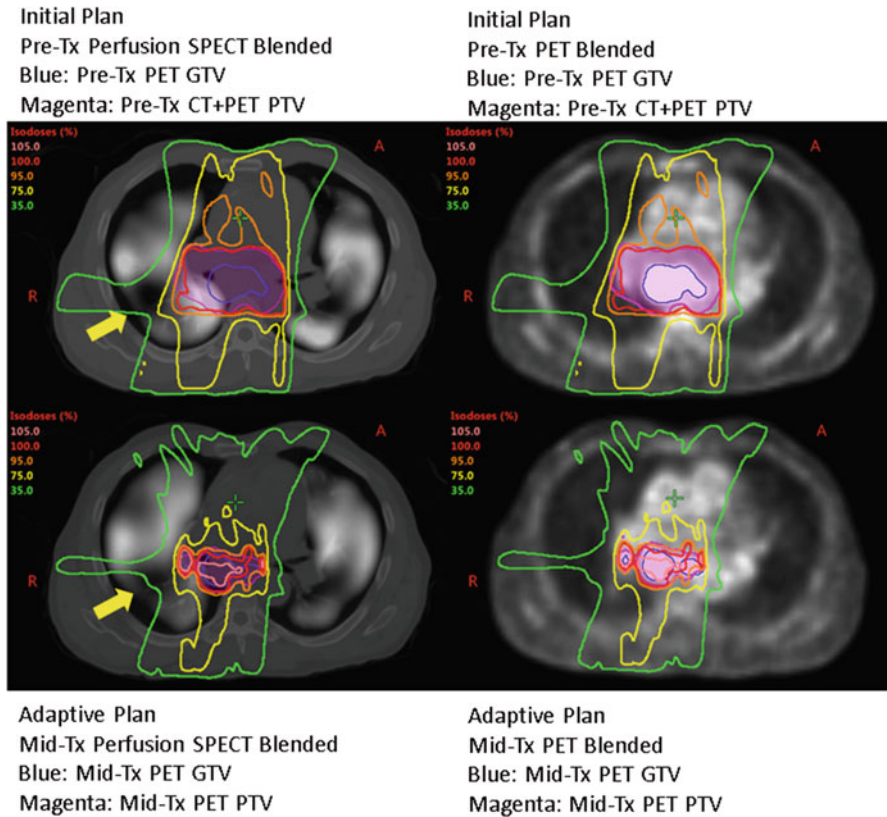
Top panels:* Initial plan treating CT+PET defined PTV (magenta) and avoiding highly perfused lung (*top left:* pre-treatment perfusion SPECT shown blended with planning CT, *top right:* CT+PET). The yellow arrow indicates a low perfusion lung area that is being preferentially dosed to avoid highly perfused areas. *Bottom panels:* Adaptive plan treating only a PET defined PTV (red). The PET is shown blended with the planning CT (*bottom right*). The during-treatment SPECT scan is also used for functional avoidance (*bottom left*)
